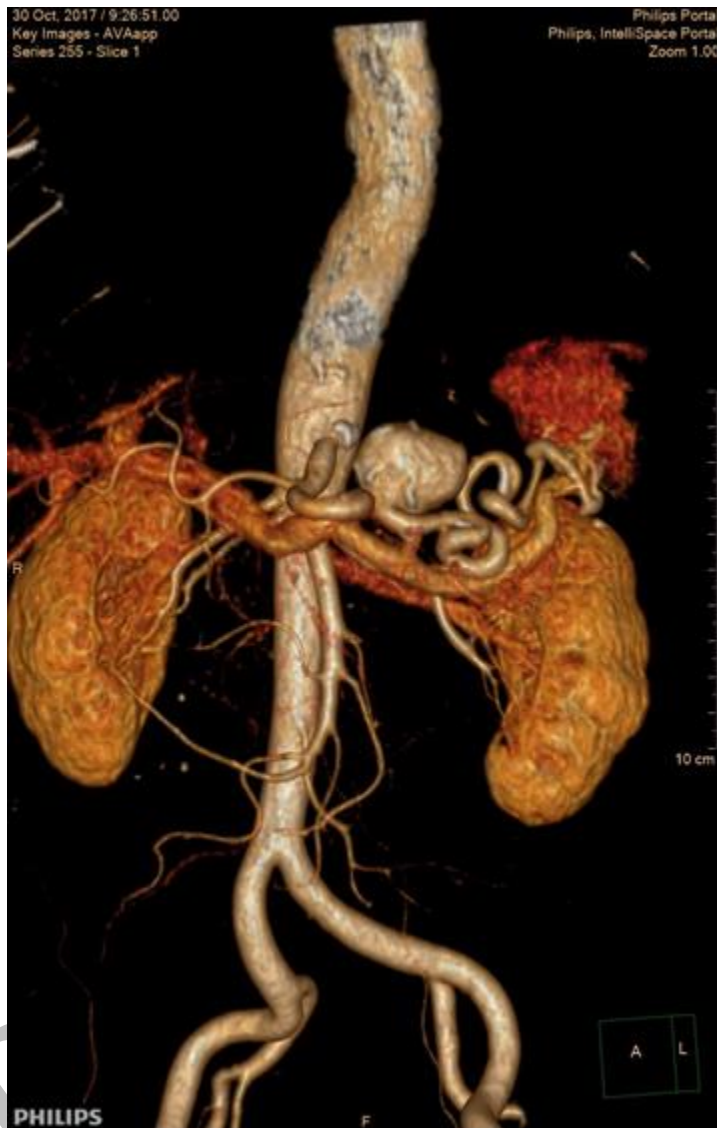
Multidetector computed tomography angiography; splenic artery aneurysm – 32 mm
